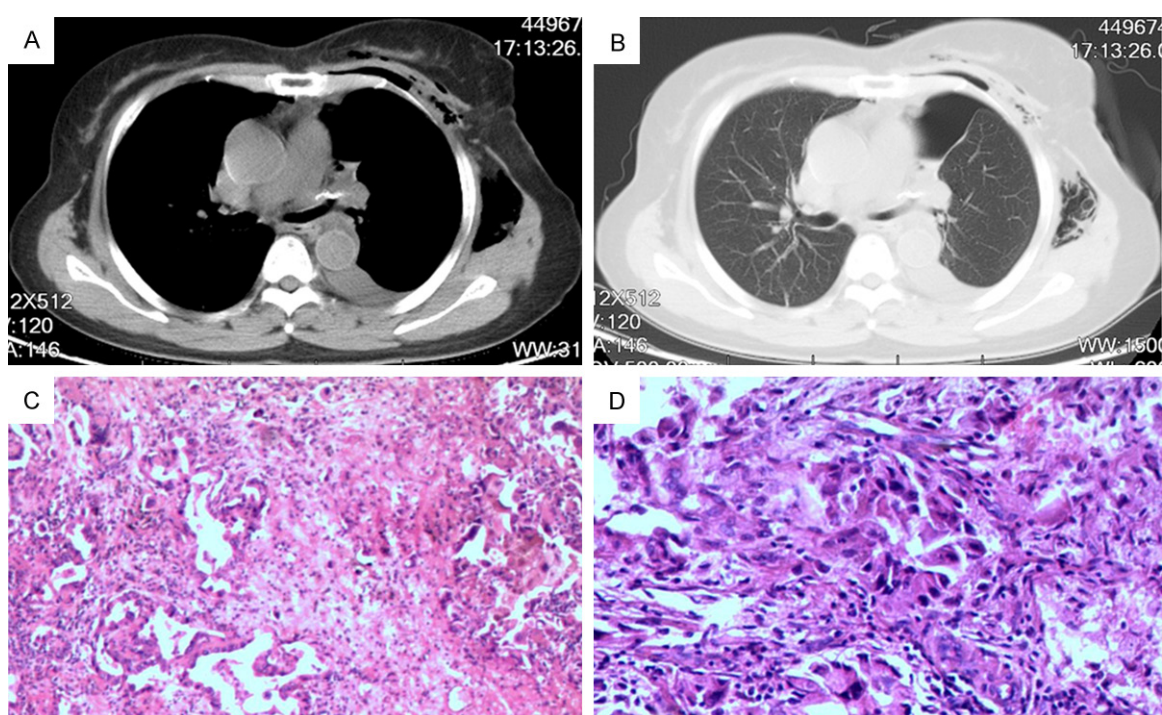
Postoperative CT and postoperative pathology. A. (mediastinal window) and B. (pulmonary window), post-operative CT scan showed that the patient underwent left upper lobe resection. C and D. Postoperative pathology confirmed that the lesion was adenocarcinoma (acinar and adherent growth pattern) (magnification, 400 ×).
